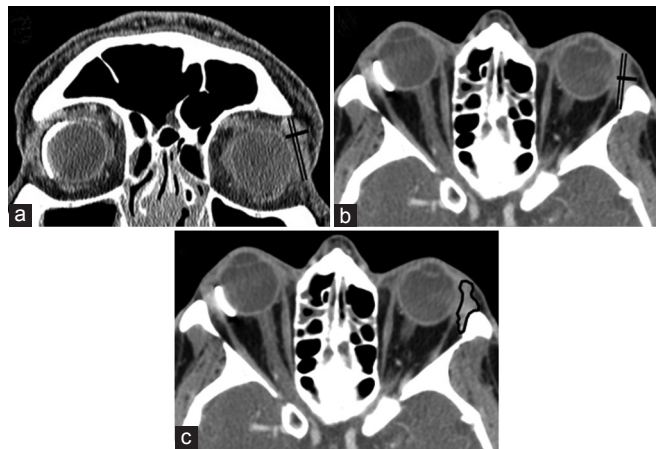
Maxillofacial CT images of a 55-year-old patient with a history of BGI placement 5 years previously depicting lacrimal gland measurements including (a) coronal vertical length (thin double line) and width (thick single line), (b) axial length (thin double line) and width (thick single line), and (c) gland outline for volume calculation.
